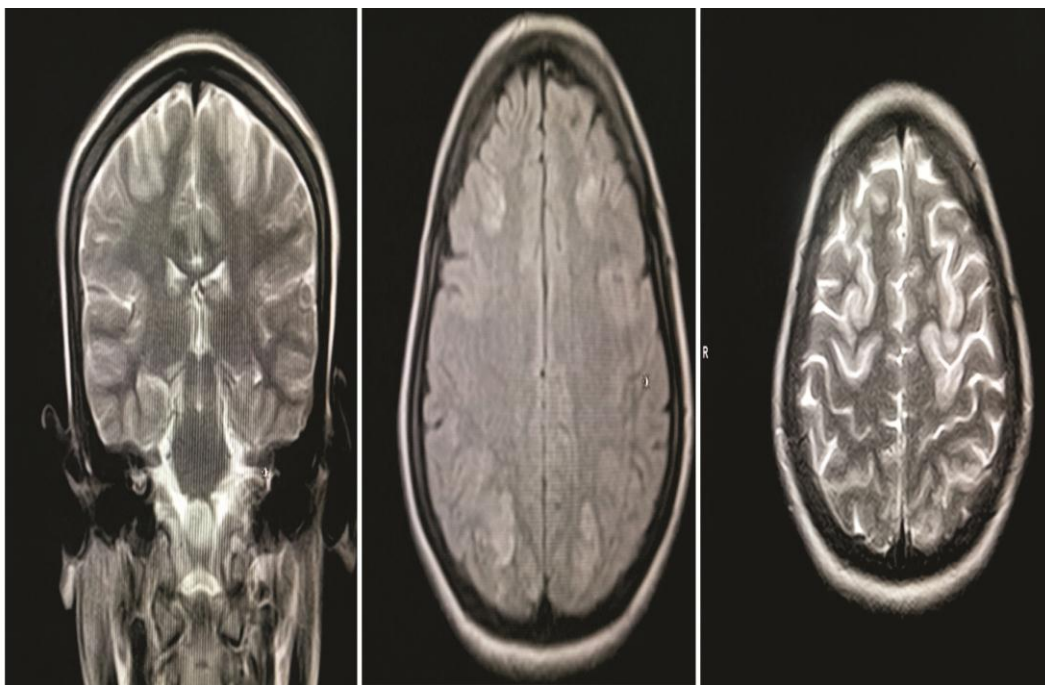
MRI brain coronal T2 and axial T2 and FLAIR images revealed hyperintensities in bilateral parieto-occipital lobes suggesting PRES—posterior reversal encephalopathy syndrome
